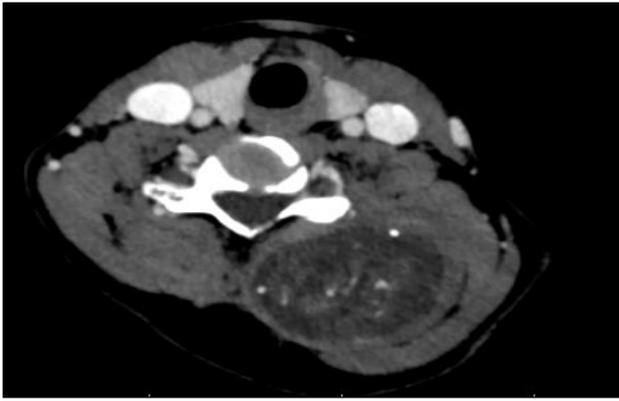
CT neck sagittal view shows an evidence of a hypo dense lesion in left posterolateral compartment of neck extending from C-3 to C-9 vertebral level with small specks of calcification, likely to be a neurogenic neoplastic tumour.
